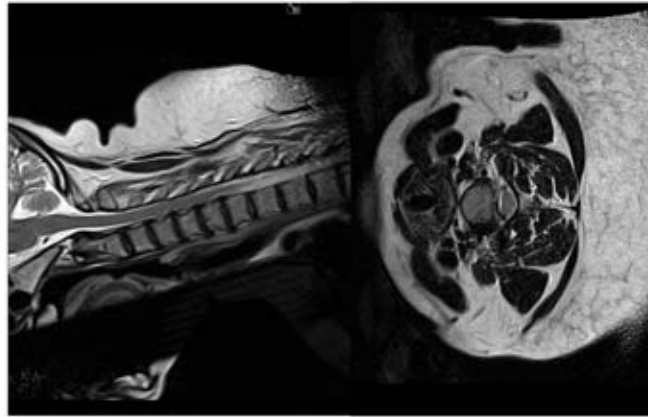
MRI Lumbar spine without contrast demonstrated lumbar joint hypertrophy and facet arthropathy with moderate to severe right foraminal stenosis with impingement of the right C6 nerve root.
